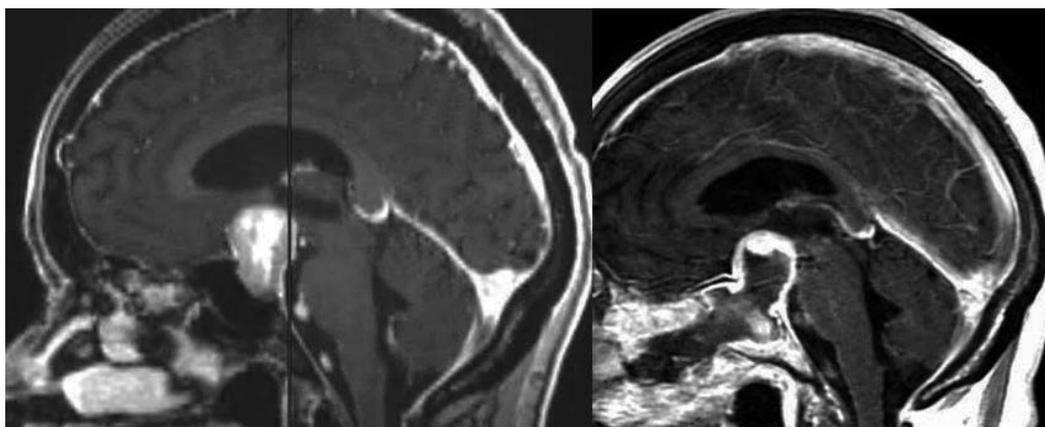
Post contrast sagittal preoperative and intraoperative sagittal MRI scans for a 76 year old female with a large pituitary macroadenoma, tumor capsule failed to prolapse into field during resection, visual inspection following imaging showed mostly blood products with a small amount of residual tumor along the superior aspect, given the patients age and preoperative visual status it was decided that a more aggressive resection was not in the patients best interest.
